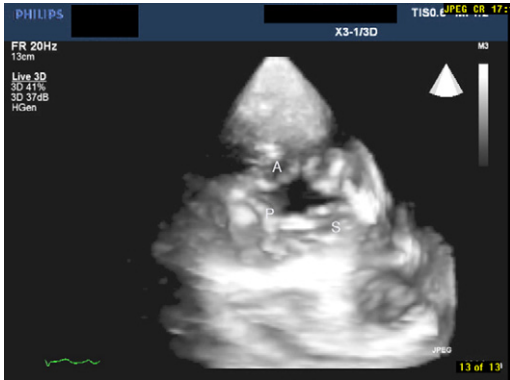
Parasternal long axis FV. Full-volume acquisition is shown obtained from the parasternal long axis view. The view is seen looking into the right atrium from the parasternal long axis and was obtained by angling toward the right heart and cropping from the right ventricle apex toward the tricuspid valve to show this tri-leaflet tricuspid valve. The view is looking into the right atrium (case 5).
